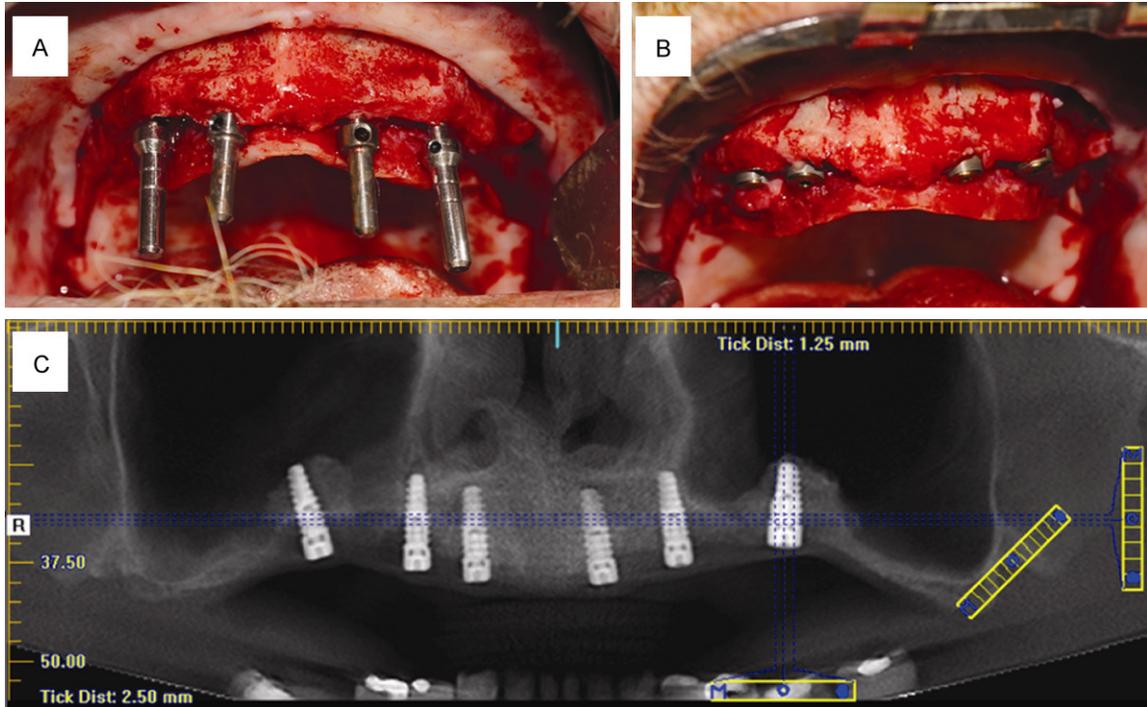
Clinical view of implant placement (A and B). Note the vestibular bone augmented after insertion of mineralized cancellous bone allograft mixed with PRF (B). CBCT shows that the gain of bone permitted six implants placement in a patient with poor bone structure before sinus lift and alveolar bone augmentation surgery (C).
